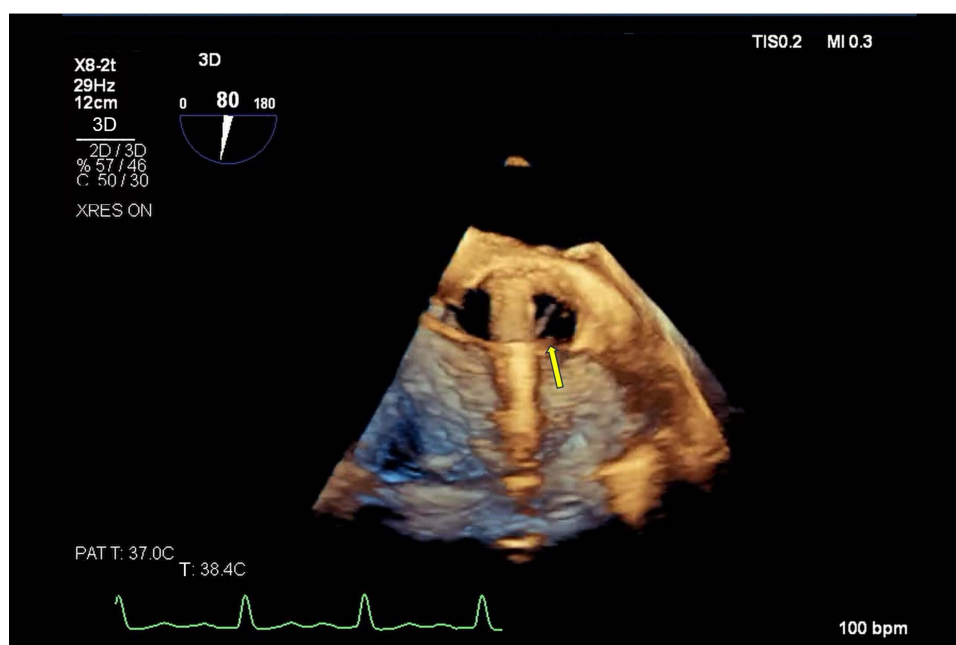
Three-dimensional transesophageal echocardiography showed no vegetation attached to the aortic valve (yellow arrow).
